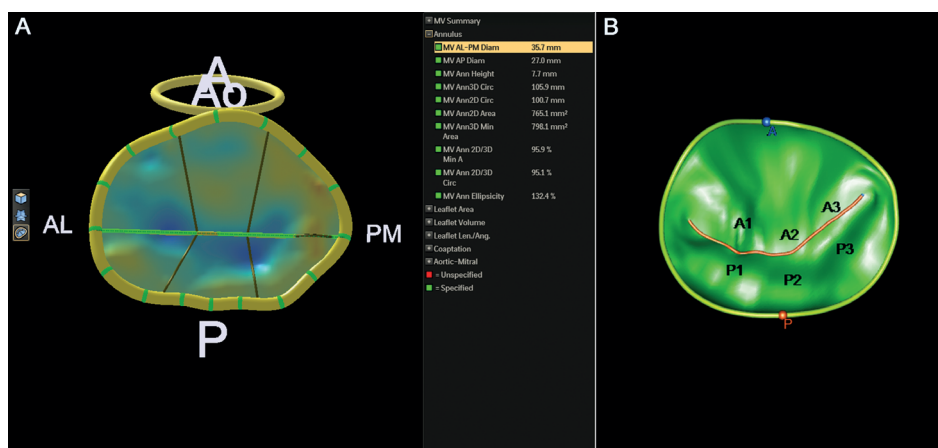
Three-dimensional echocardiographic surgical view reconstruction of the mitral annulus with software from Philips QLAB (A) and TomTec (B).
